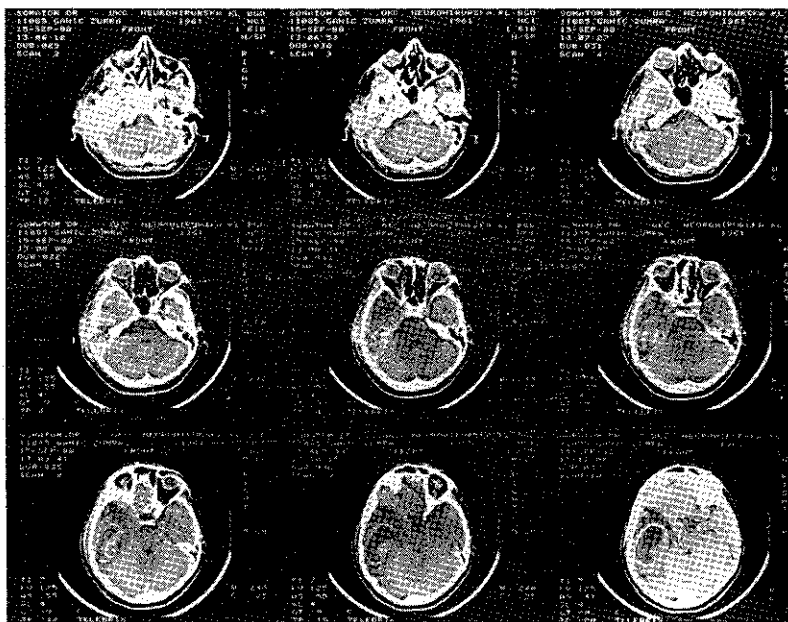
Computed tomography with contrast showing tumor extension towards the left pyramidal apex. Note destruction of the mastoid, cavum tympani and partially the left temporal bone squamae. An encapsulated left temporal lobe abscess is shown. The basal cisterna and the chamber system were completely shifted to the right side.
